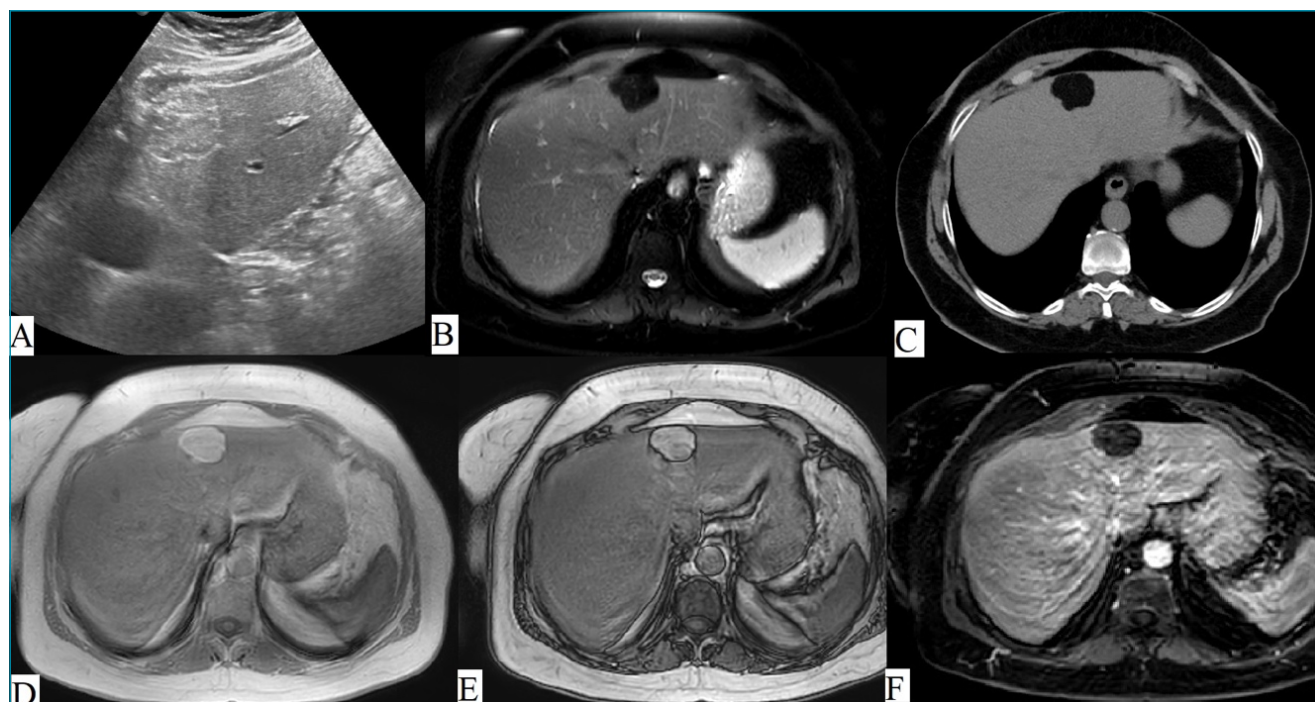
(A) Ultrasonography image reveals a hyperechoic lesion at segment 2 of the liver. (B) Axial fat-saturated T2-weighted image shows a hypointense lesion. (C) In the axial computed tomography image, the lesion is hypodense. (D) and (E) Dual gradient echo in-phase and opposed-phase images demonstrate a hyperintense lesion with a chemical shift artifact at the periphery of the lesion. (F) There is no contrast enhancement on the axial T1-weighted image. Images of a 58-year-old woman with a hepatic lipoma.
